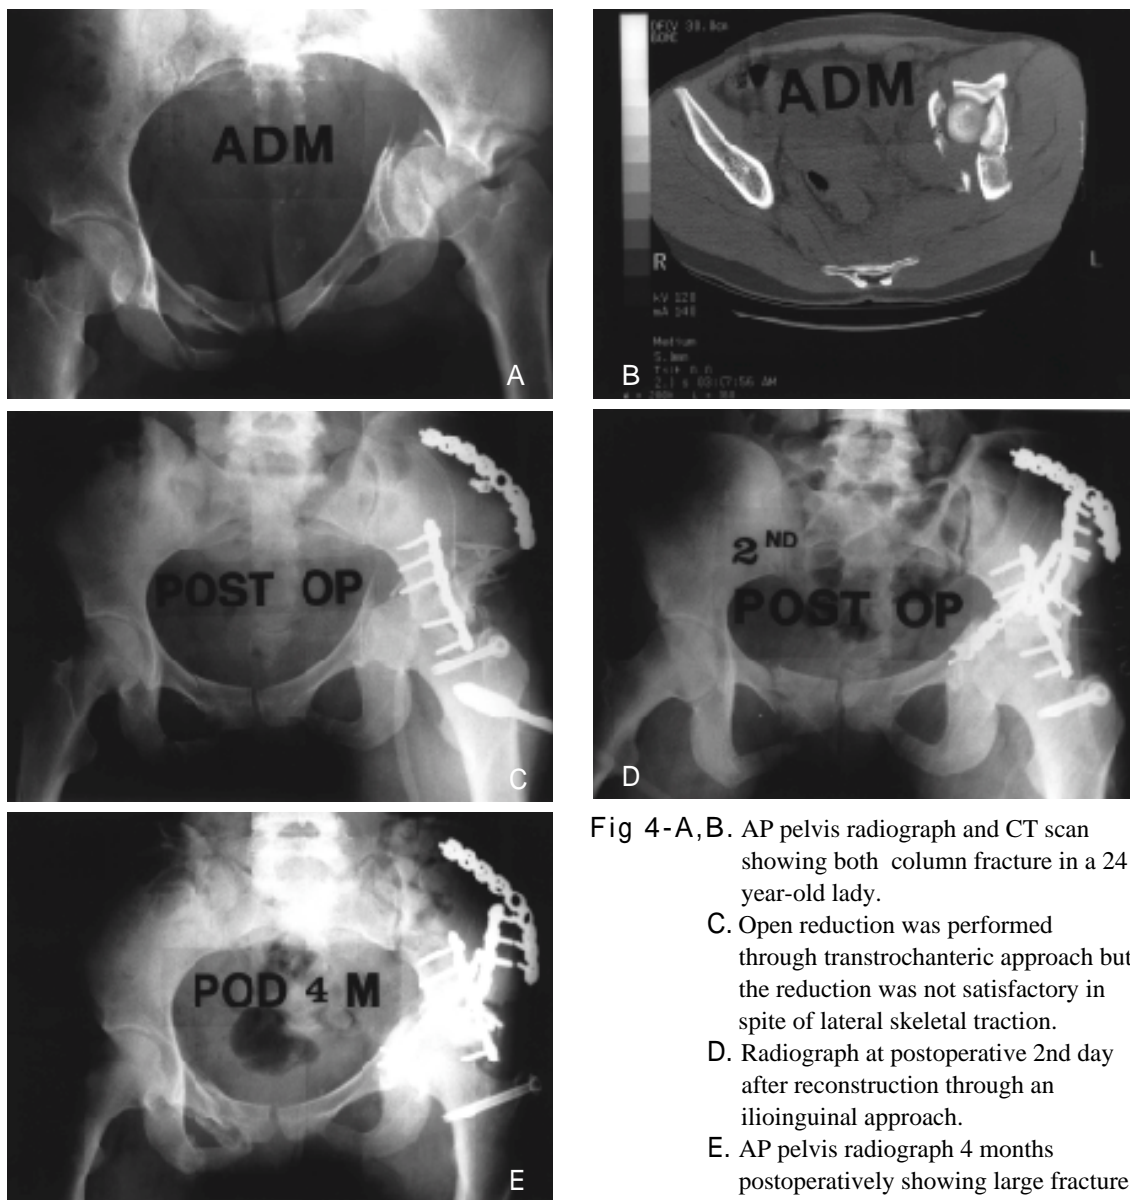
AP pelvis radiograph and CT scan showing both column fracture in a 24 year-old lady.
